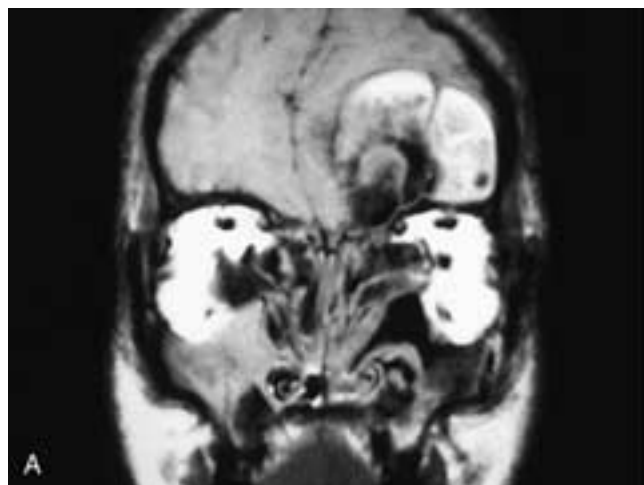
Coronal (A) and sagittal (B) T1-weighted MR images show multiple sinonasal polypoid masses that have extended into the medial aspect of each orbit, broken through intracranially, and obstructed the maxillary sinuses. These are areas of high, intermediate, and low signal intensity throughout the lesion, as well as areas of signal void. This patient had polyposis from aspirin intolerance.
